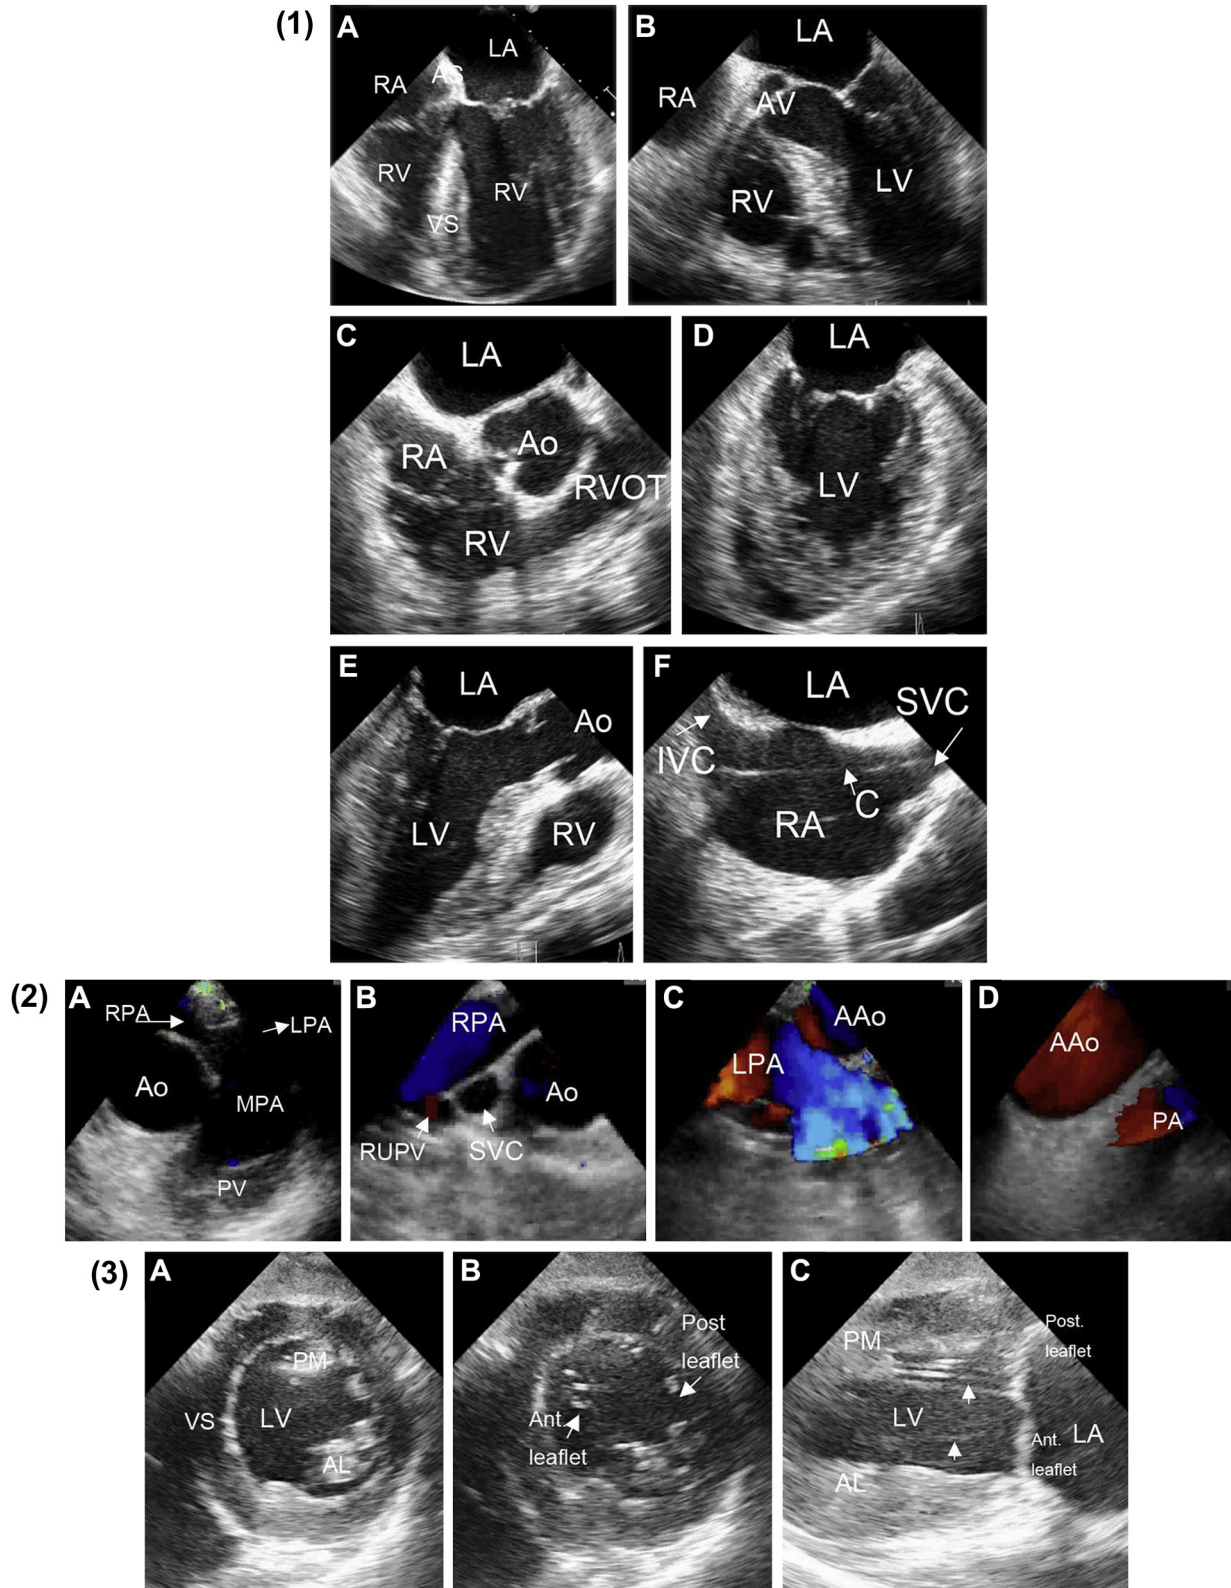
(1) The mid-esophageal views of transesophageal echocardiography (TEE). (A) Four chamber view at 0 degrees; (B) five chamber view at 0 degrees; (C) right ventricle (RV) inflow-outflow view at 80 degrees; (D) two chamber view at 90 degrees; (E) left ventricle (LV) long axis view at 120 degrees; and (F) bicaval view at 90–120 degrees. (2) The upper-esophageal views of TEE. (A) main pulmonary artery (MPA); (B) right pulmonary artery (RPA); (C) left pulmonary artery (LPA); and (D) ascending aorta (AAo). (3) The transgastric views of TEE. (A) short axis view for papillary muscle; (B) short axis view for mitral leaflet; and (C) long axis view for chordae apparatus (arrow). AL = anterolateral papillary muscle; Ao = aorta; AV = aortic valve; C = central venous catheter; IVC = inferior vena cava; LA = left atrium; LV = left ventricle; PA = pulmonary artery; PM = posteromedial papillary muscle; PV = pulmonary valve; RA = right atrium; RUPV = right upper pulmonary vein; RV = right ventricle; RVOT = right ventricle outflow tract; SVC = superior vena cava; VS = ventricular septum.
